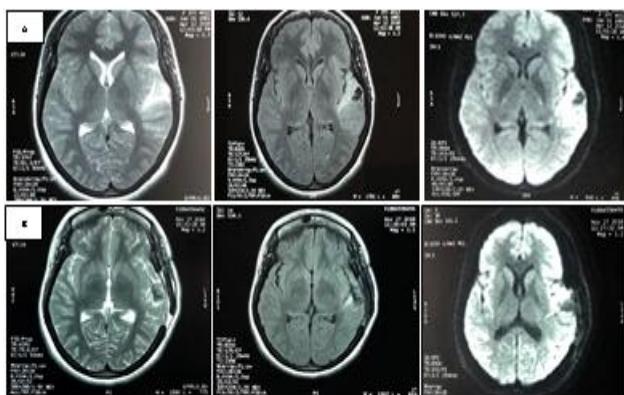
Pre-operative (A) and post-operative (B) MR imaging, from left to right axial T2, T2 flair and diffusion sequences
